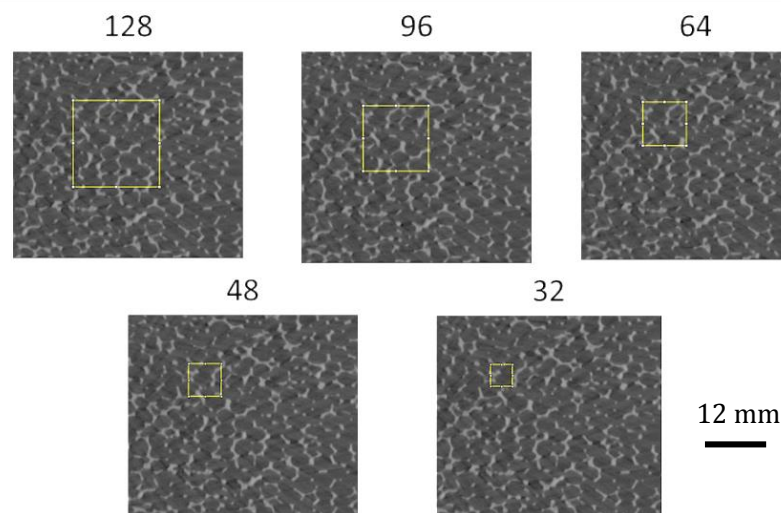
CT slices with sub-volume of different sizes in relation to features of the foam.
